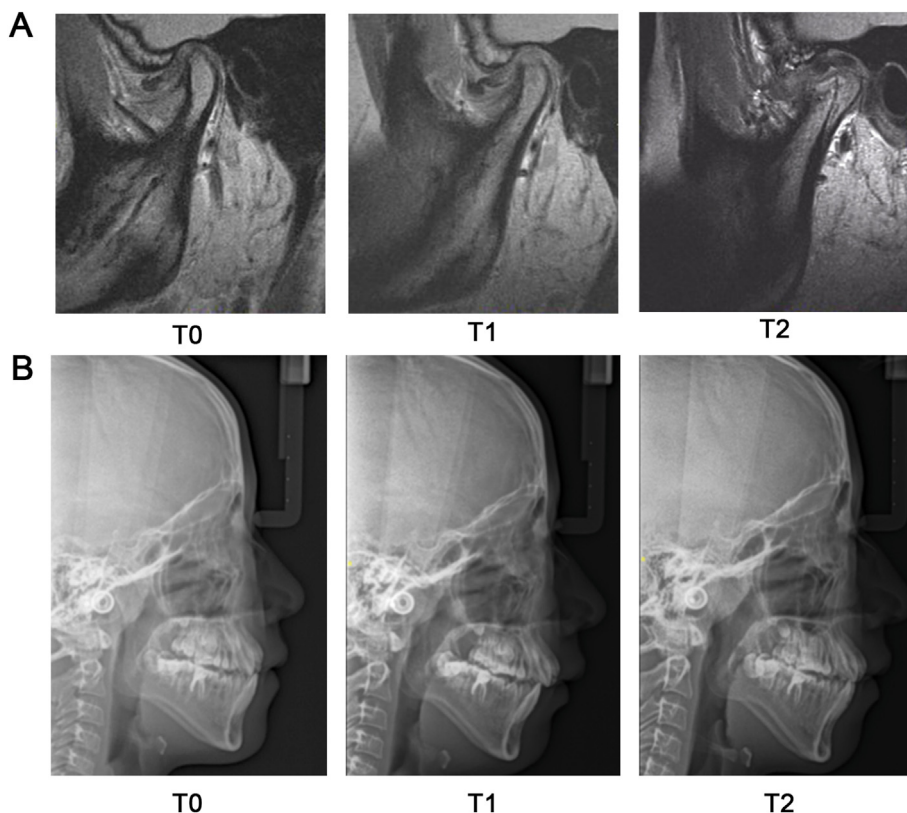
(A) Magnetic resonance images of lateral and posteroanterior cephalometric radiographs of a representative case from T0 to T2. (B) Lateral and posteroanterior cephalometric radiographs. T0, the beginning of the natural course; T1, within 1 week before arthroscopic surgery; T2, the last follow-up after arthroscopic surgery.
